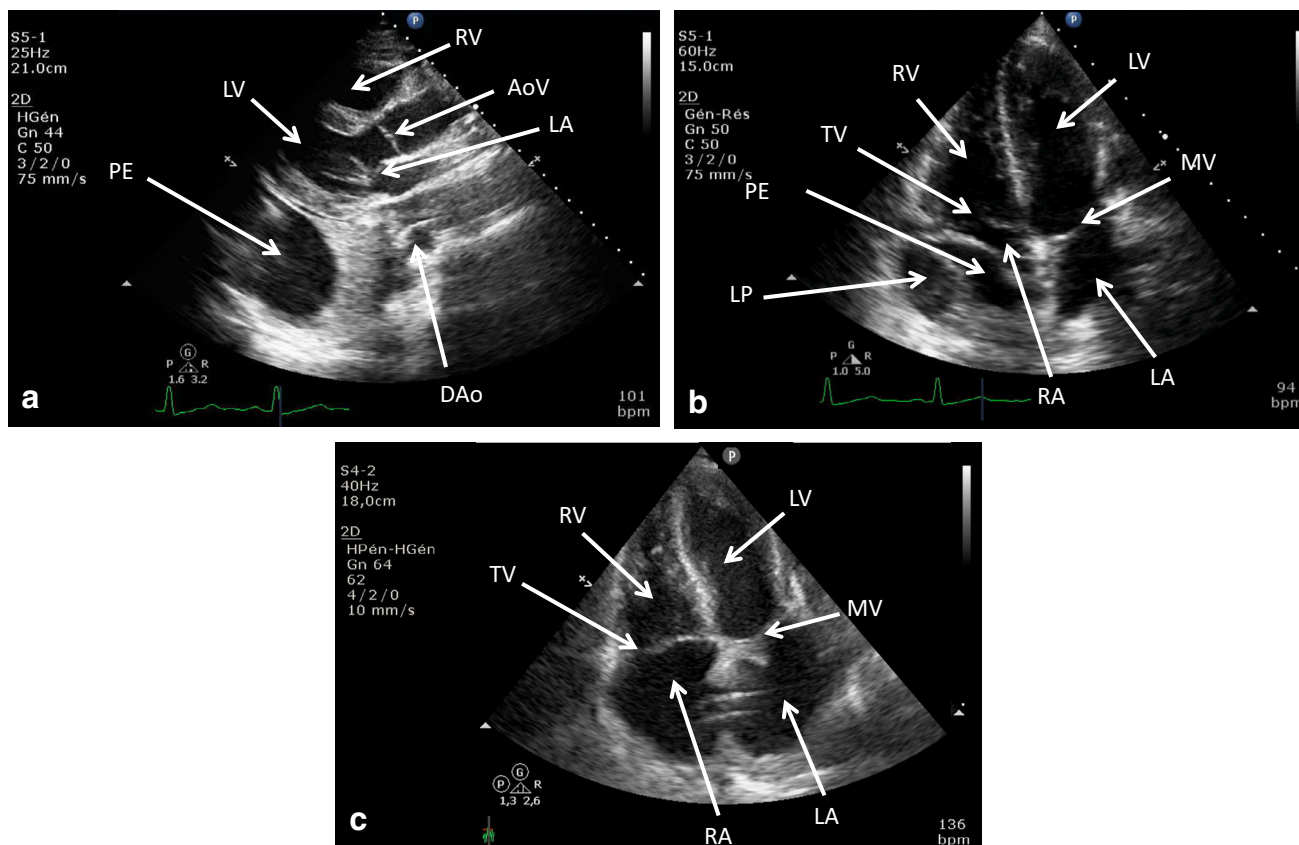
Transthoracic echocardiography showing a (parasternal long-axis view) a large pleural effusion, b (apical 4-chamber view) the same large pleural effusion leading to a diastolic right atrial collapse, and c (apical 4-chamber view) after pleural drainage, no
